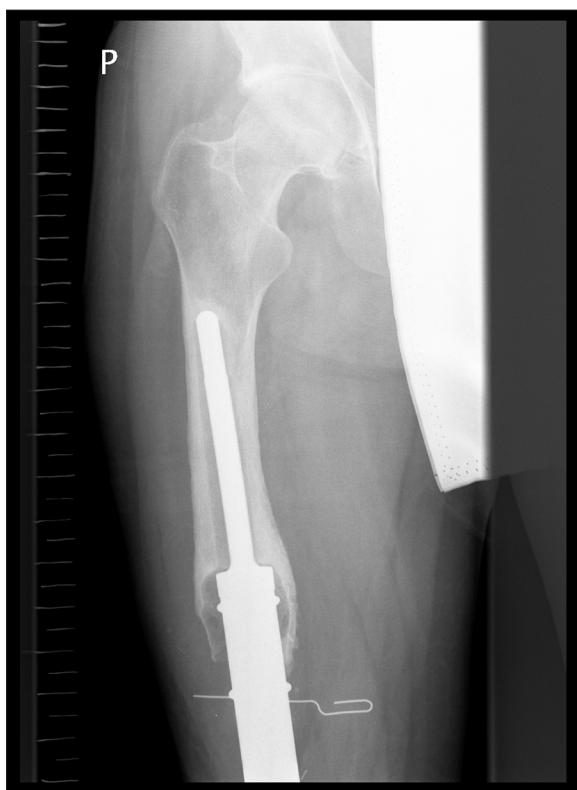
26-year-old patient with femoral osteosarcoma five years after implantation of endoprosthesis. X-ray: loosening of the prosthesis at the level of the femoral stump.
